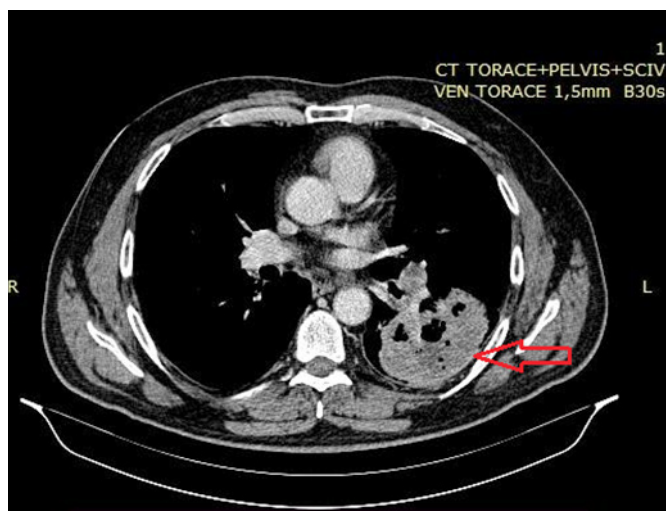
Thoracic angio-CT, axial section.
